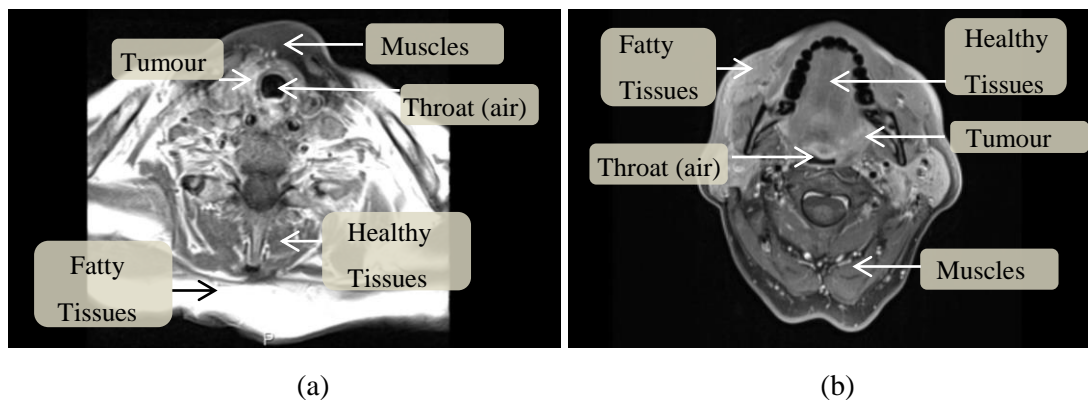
Five main tissue types (labelled) observed on axial MRI slice of (a) larynx and (b) oropharynx (BoT) in presence of a primary tumour (GTV).
